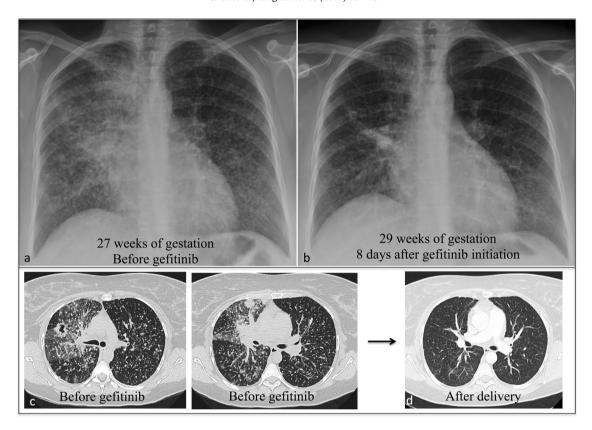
(a) Chest radiograph before the beginning of gefitinib when patient required 3 L/mn of oxygen supplementation. (b) Reflects change after one week of gefitinib administration when patient is breathing room air. (c and d) Exhibit chest CT-scan at diagnosis and immediately after delivery when patient had received gefitinib for two months
